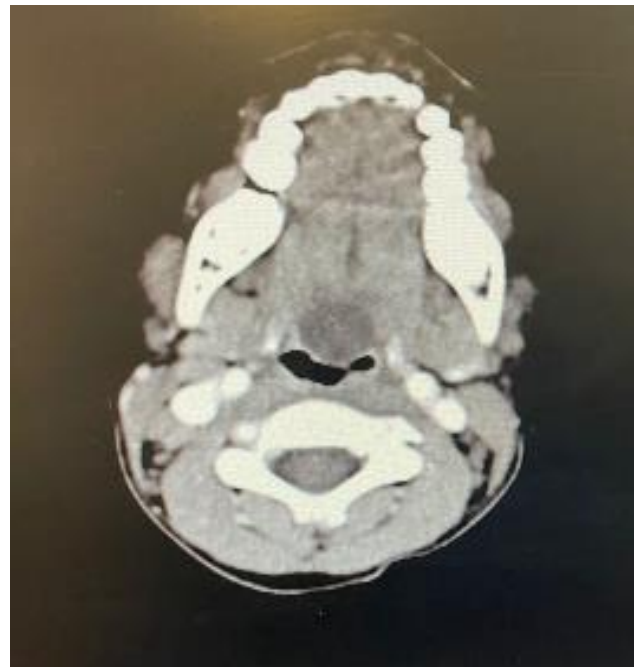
Axial Computed Tomography imaging showing a hypodense cystic lesion of the vallecular.
